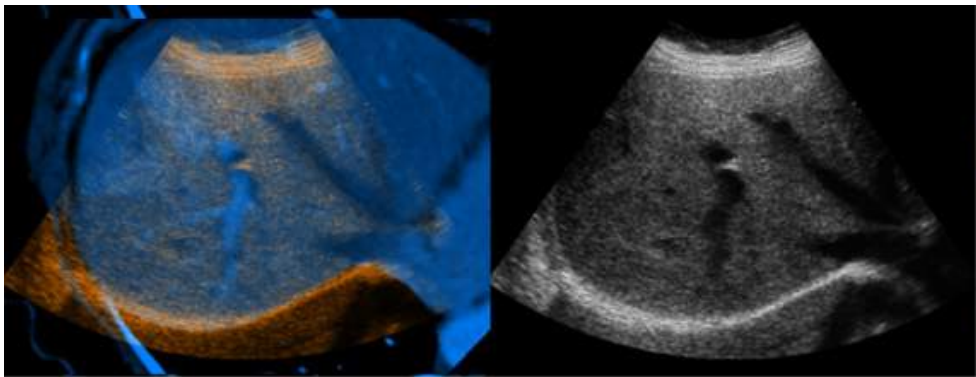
An example of US-CT image fusion result, from [WBK<sup>+</sup>08].
